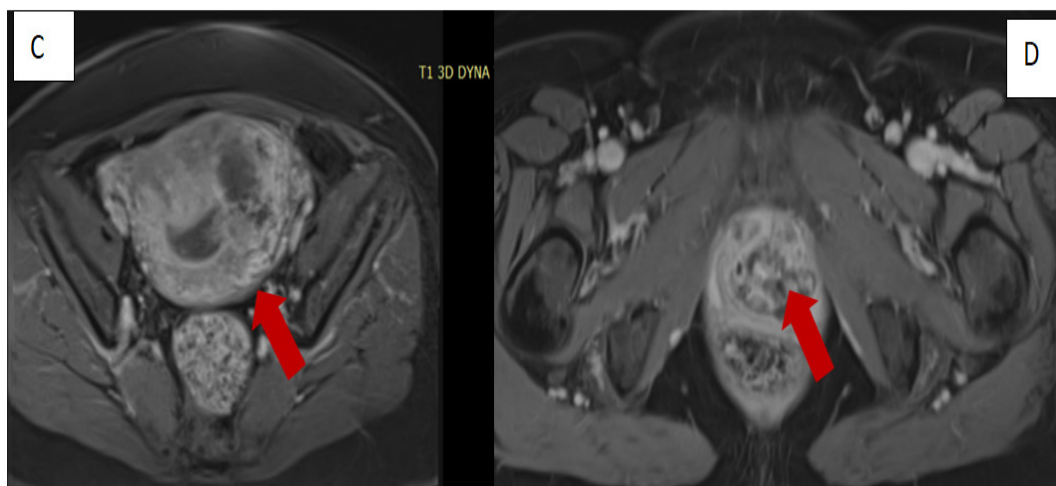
Axial T1-weighted images after gadolinium injection (C,D) showing heterogeneous enhancement of the lesion (red arrow).
